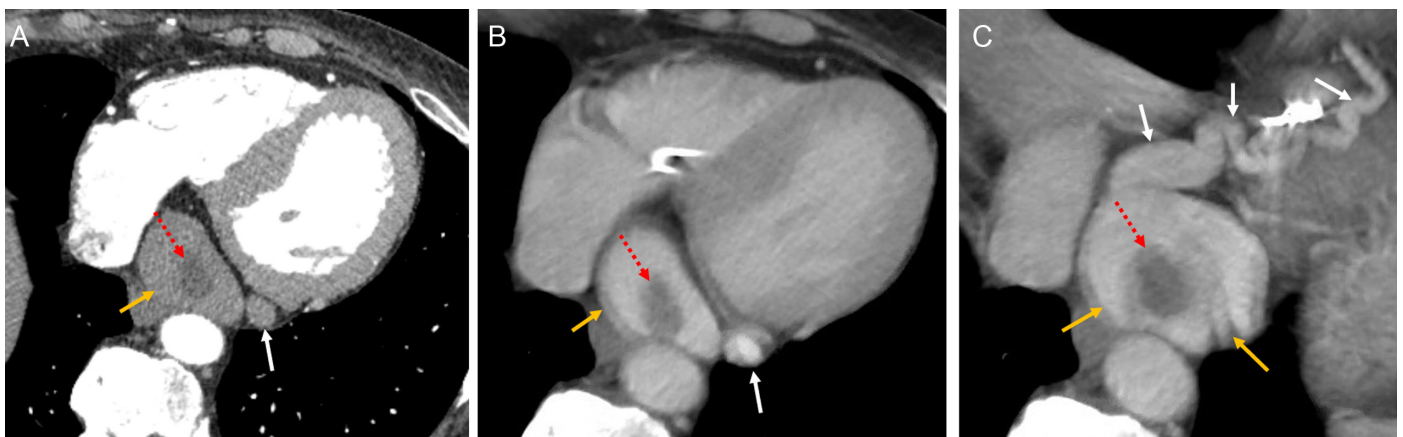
Axial chest computed tomography (CT) angiography (A) and venous phase CT (B) images show enlarged coronary sinus (yellow arrows), a low attenuation filling defect within the coronary sinus (dashed red arrows), and lower part of the persistent left superior vena cava (white arrows). Axial venous phase CT (C) image at the level of posterior interventricular sulcus shows enlarged coronary sinus (yellow arrows), a low attenuation filling defect within the coronary sinus consistent with thrombus (dashed red arrow), and dilatation of the middle cardiac vein (white arrows).
